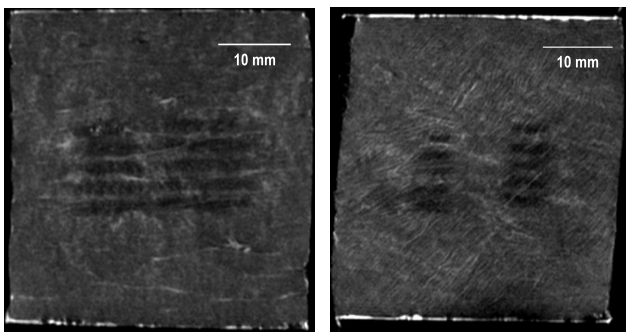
T1-weighted MR images of axial sections of 10 necrotic lesions created in the tissue sample after its sonication on both sides by 5 HIFU beams with 1.08 MHz (left) or 3.21 MHz (right) frequency, 0.3-s pulse duration and 0.6 duty-cycle.
